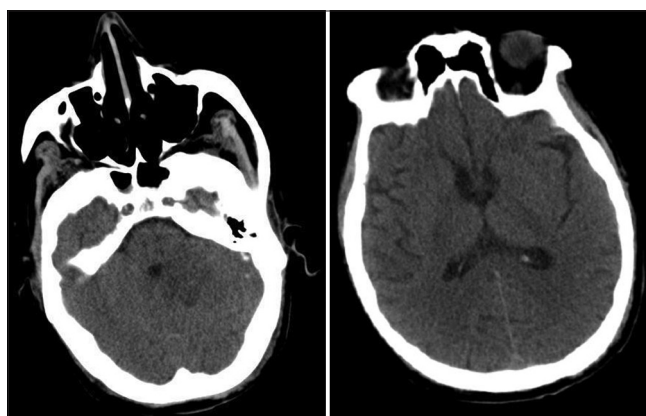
Postoperative head computed tomography revealing a reduction of the lesion with reexpansion of the fourth ventricle (left) and resolution of hydrocephalus (right)
